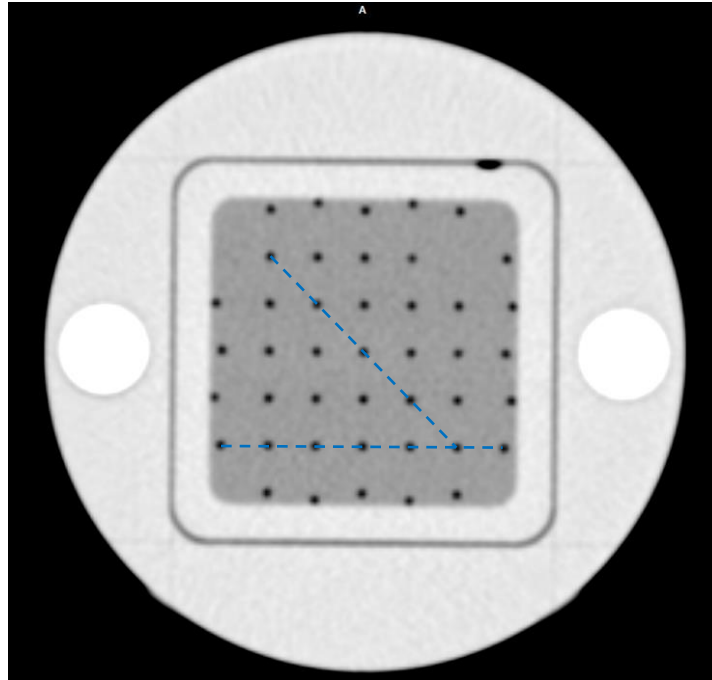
Axial CT scan of grid insert. Grid dimensions were measured along the long dimensions (60 mm) and diagonal (shown as dashed lines) in the central and peripheral sections of the grid.
